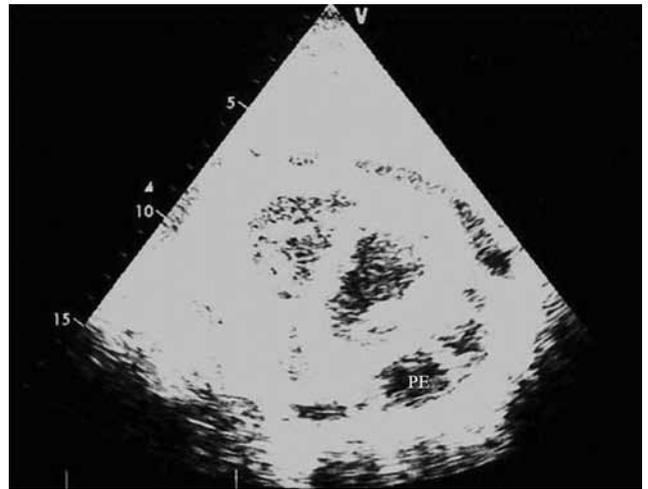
Two-dimensional echocardiogram showing a large pericardial effusion (PE).
